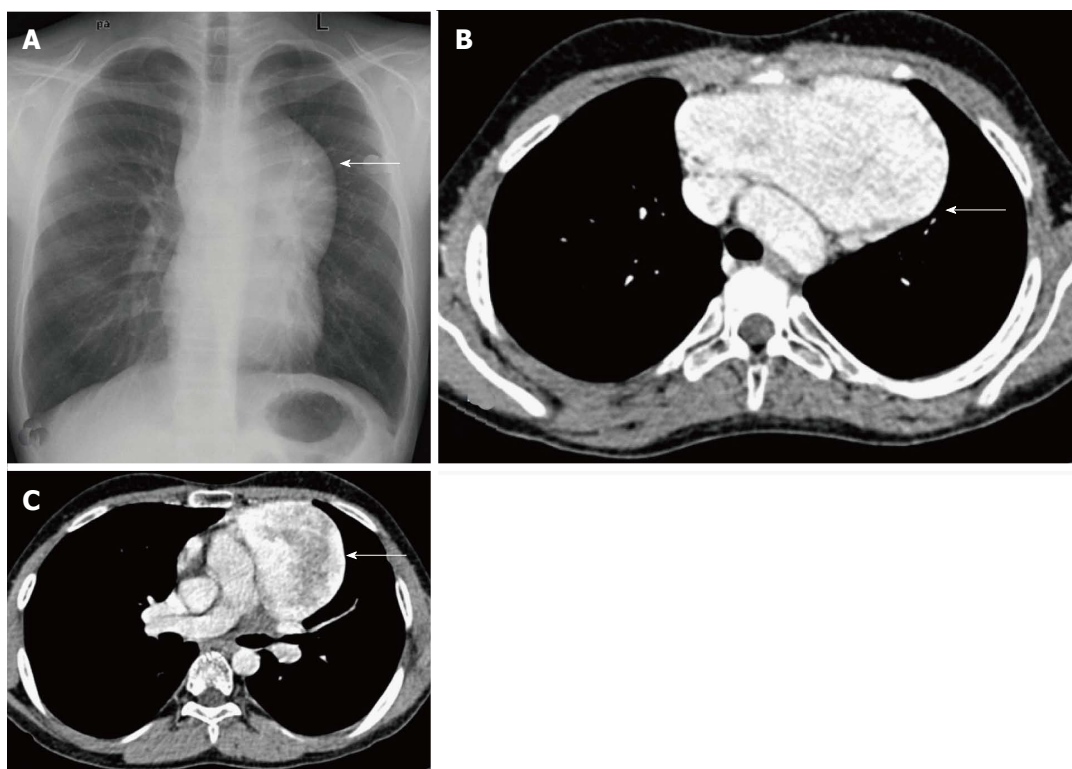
Incidentally detected cavernous hemangioma in 16-year-old male. Frontal chest radiograph (A) reveals a well-defined, lobulated soft tissue density mass (arrow) with broad base towards the mediastinum and positive hilum overlay sign. CECT axial sections (B and C) show a sharply margined mass lesion (arrow in B) anterior to the arch of the aorta. Note the intense post contrast enhancement with central heterogeneity (arrow in C).
